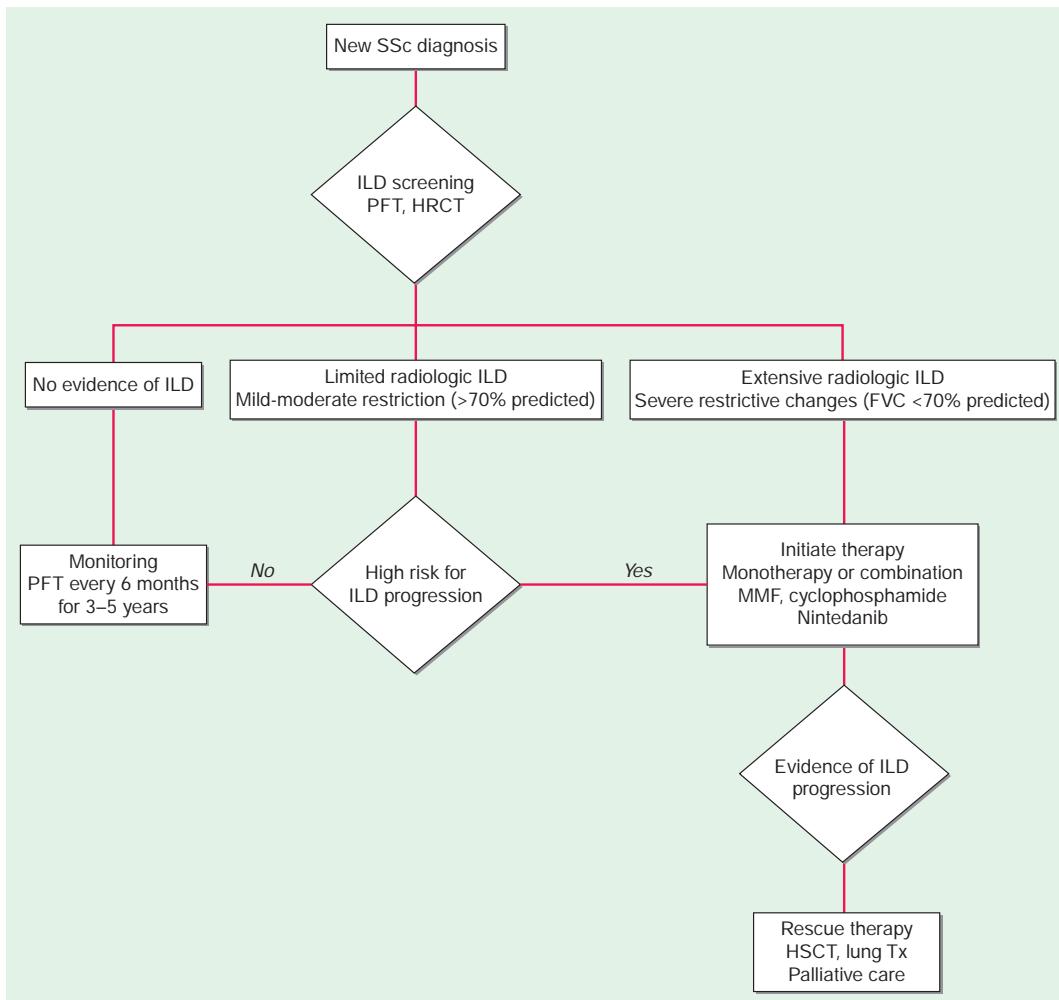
Proposed algorithm for screening, monitoring, and treatment of systemic sclerosis (SSc)-associated interstitial lung disease (ILD). FVC, forced vital capacity; HRCT, high-resolution computed tomography; HSCT, hematopoietic stem cell transplantation; MMF, mycophenolate mofetil; PFT, pulmonary function testing; Tx, transplantation. (Adapted from A Perelas et al: *Lancet Respir Med* 8:304, 2020.)
